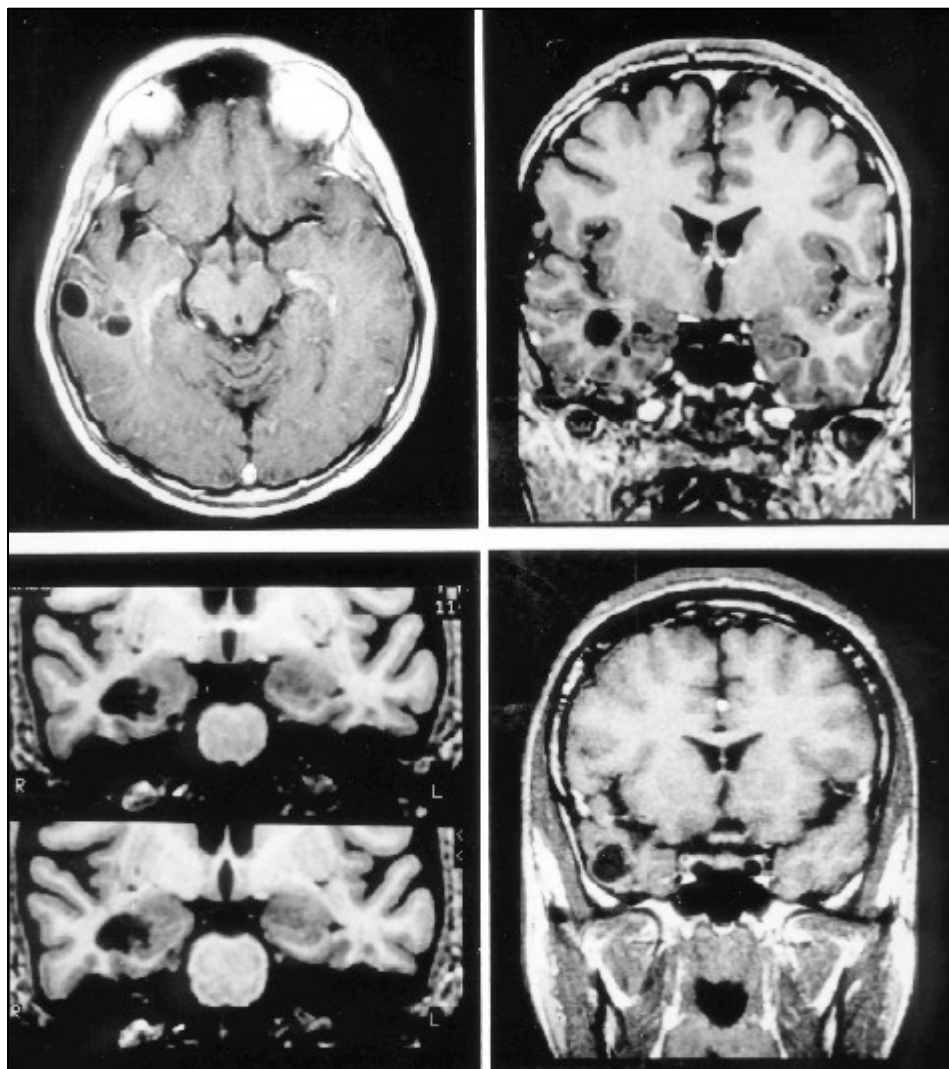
MRI pre operative with similar characteristics in four patients with different pathological diagnosis: (A) ganglioneuroma, (B) pilocytic astrocytoma, (C) dysembrioplastic neuroepithelial tumor and (D) ganglioma.
